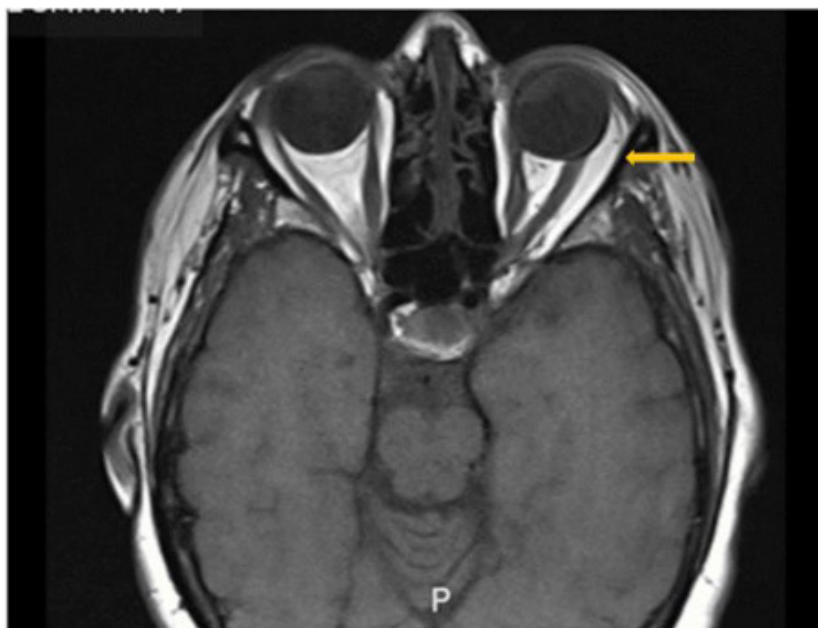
Axial T1-weighted magnetic resonance imaging (SIGNA MR750w, GE Healthcare, Waukesha, WI, USA) of the brain and orbits without fat-suppressed contrast enhancement. The image shows left eye esotropia with contracted medial rectus muscle and fibrotic and atrophied lateral rectus muscle (yellow arrow).
